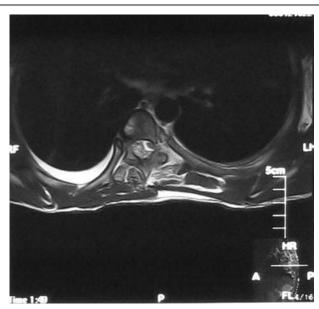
Magnetic resonance imaging revealed that spinal-cord cavernous hemangioma in the Thoracic 4 level of the spinal cord.
